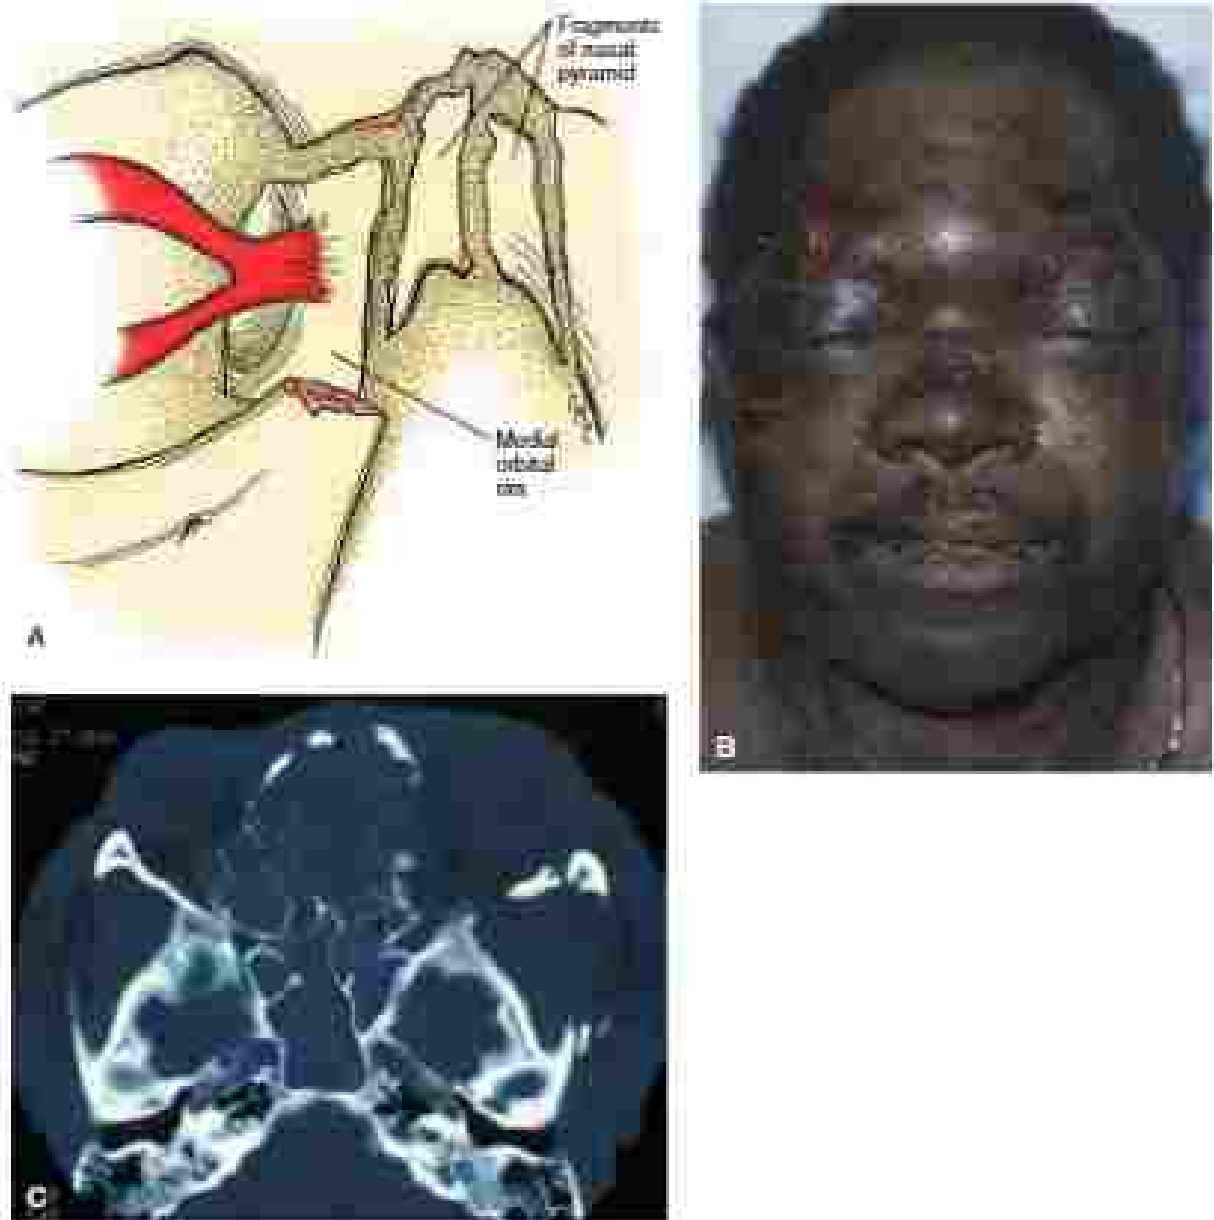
(A) The canal sign of a nasoorbital orbital fracture is the lower rim thick of the medial orbital rim. Here, the medial orbital ligament attaches to the frontal process of the nasal bone. Dislocation of the frontal process of the nasal bone disrupts the entire canal complex. (B) A patient with nasoorbital orbital and a LeFort II fracture. Flattening of the nose and bilateral periorbital hematomas are seen. (C) Radiograph (computed tomography scan) of the patient's nose at post.
